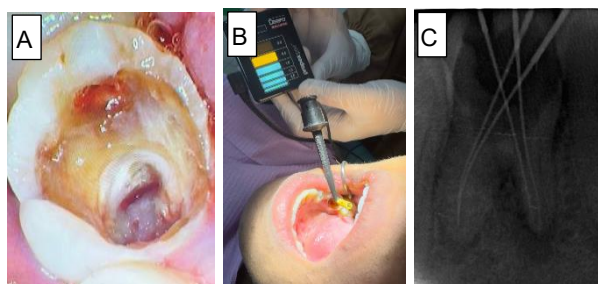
Access Opening (A); Working length determination using EAL (B); Periapical radiograph confirming actual working length with K-file (C)
